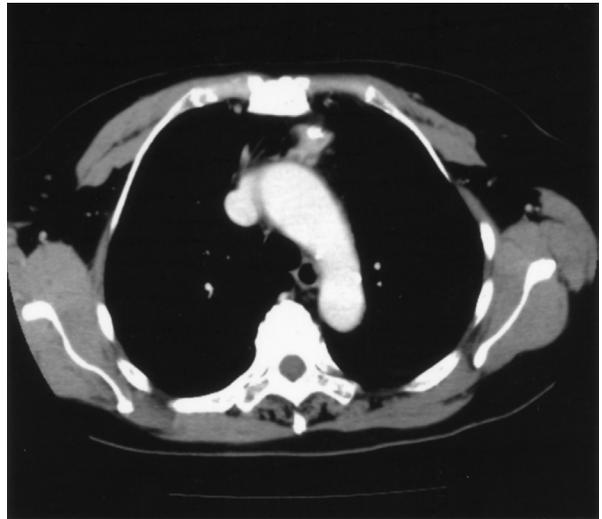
Chest CT reveals an anterior mediastinal irregular-shaped soft tissue mass with calcification.
